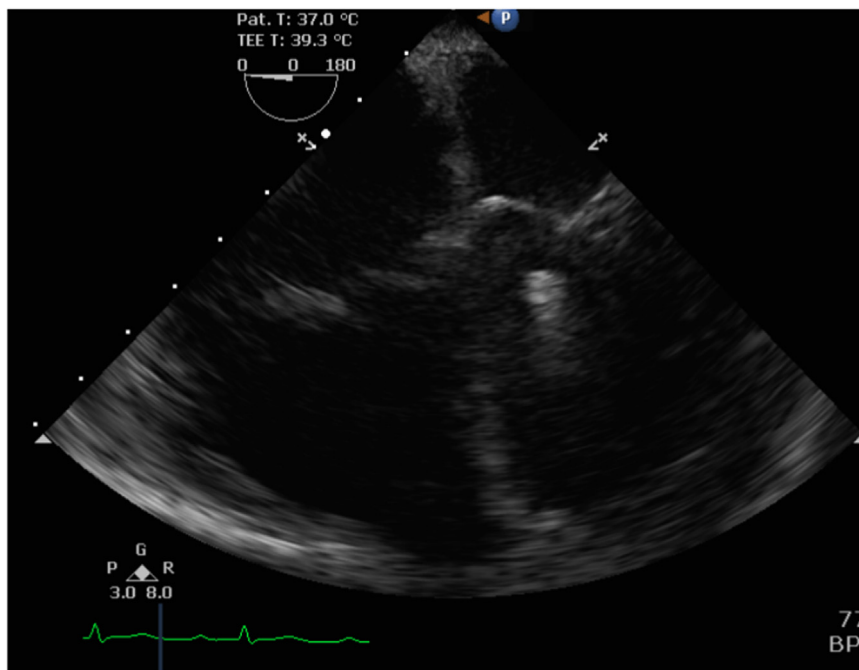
Transesophageal echocardiograph demonstrating left ventricular finger-like projection attached to the posteromedial papillary muscle.
